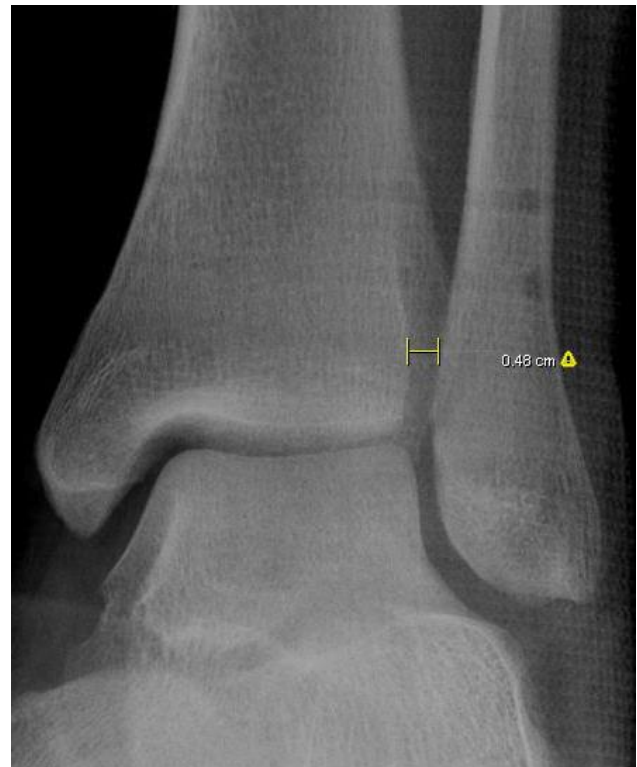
Tibiofibular clear space measurement after bioabsorbable screw fixation. Average radiographic follow 6.15 months for bioabsorbable screw fixation.
